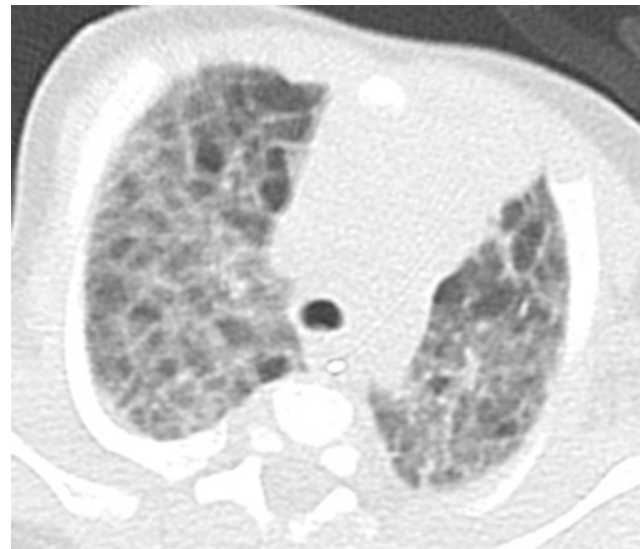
Pulmonary interstitial glycogenosis. Axial chest CT image from a 7-week-old, former 29-week preemie with hypoxemia shows both ground-glass opacities and hyperlucent pulmonary lobules. Lung biopsy revealed a growth abnormality with superimposed alveolar wall thickening related to pulmonary interstitial glycogenosis
